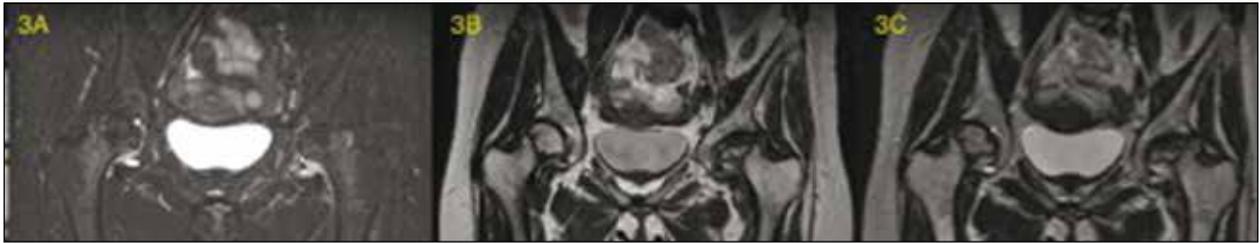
Magnetic resonance images (MRI) showing results 7-month after Figure 1A. Fracture lines in both femoral heads with mild displacement, decreased bone marrow edema compared with Figure 2, and collapse and secondary osteonecrosis in left femoral head. Panels A, B and C are respectively coronal short tau inversion recovery MR image, coronal T1-weighted MR image and coronal T2-weighted MR image sequences.
